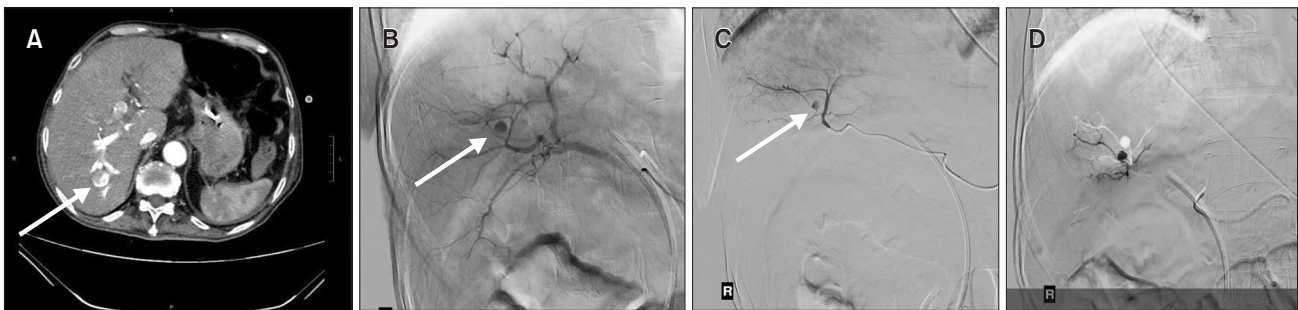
Images for Case 2. (A) Computed tomography showed a ≤ 0.6 cm pseudoaneurysm over the posterior branch of the right hepatic artery (arrow), with surrounding abnormal contrast pooling. (B) The pre-treatment right hepatic angiography showed a pseudoaneurysm (arrow) from a branch of the right hepatic artery, with no features of active bleeding. (C) The pre-treatment segment 6 segmental angiography showed a pseudoaneurysm (arrow) arising from this artery, with no features of active bleeding. (D) The post-*N*-butyl cyanoacrylate glue embolization angiogram showed complete obliteration of the segmental artery and the pseudoaneurysm.
